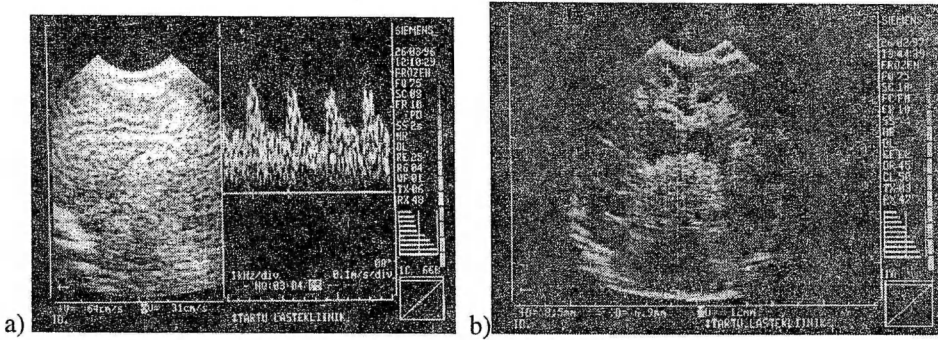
Ultrasound scan of a severely asphyxiated newborn infant with a severe stage of HIE and the IV stage of CP on follow-up.
